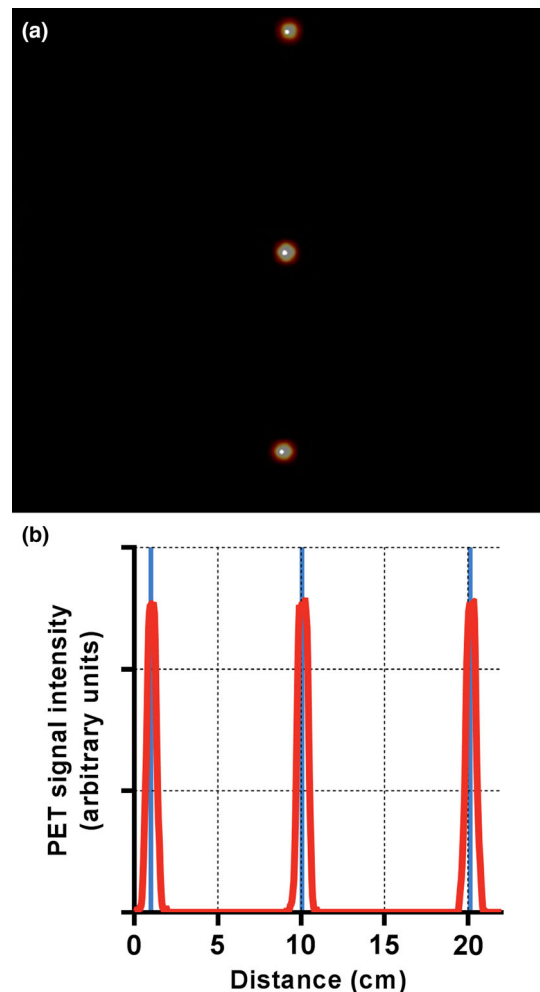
Results from the PET/CT co-registration test indicated excellent alignment. The distance between the PET and CT centroids was negligible for all sources on both the fused image (a) and the PET signal profile through the center of the image (b). Within the profile of PET signal, the solid vertical lines denote the center of the CT signal centroids. [Color figure can be viewed at wileyonlinelibrary.com]
